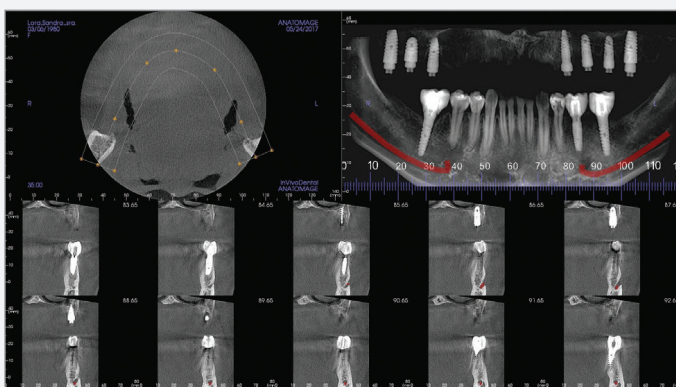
CBCT at 2-year follow-up after loading.
